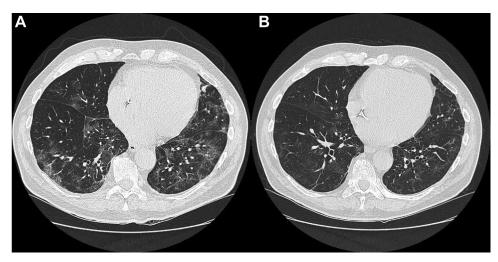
A: Computed tomography (CT) scan of the chest showing bilateral multiple ground-glass opacities. B: CT scan of the chest showing imaging improvement correlated with resolution of clinical symptoms.
